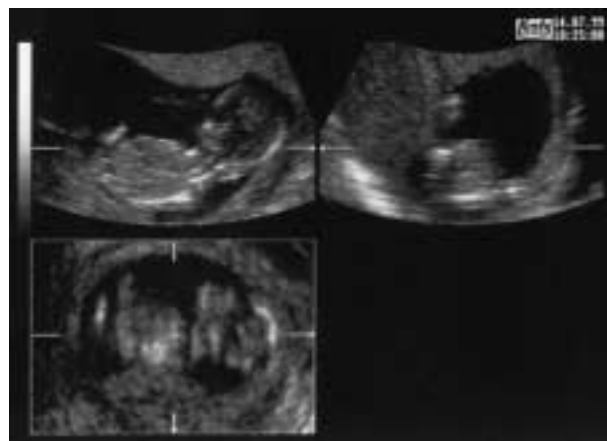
An example of random volume. The initial plane from which the volume was recorded was selected randomly with no efforts being made to optimize the angle between the fetus and the ultrasound beam (upper left image).
